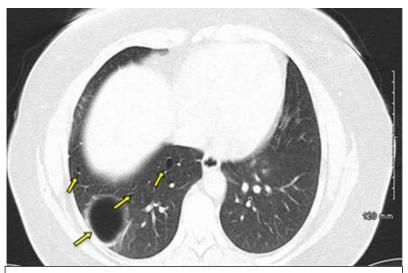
Figure <u>2</u>: Chest CT showing multiple bilateral thin-walled lung cysts (arrows) consistent with the diagnosis of Birt-Hogg-Dubé syndrome the largest of these is in the posterior basal right lower lobe and measures 5.8 cm in diameter.
